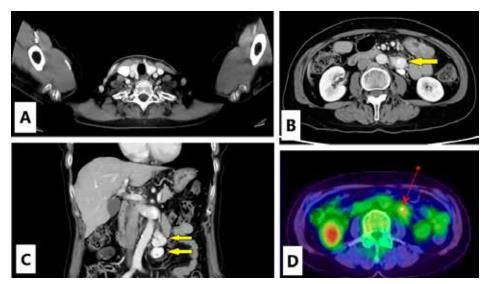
The thyroid gland was located in the normal position, and there were no neoplastic lesions in the neck. (A) On contrast-enhanced abdominal CT, the arrow indicates an approximately 2-cm mass on the left side of the abdominal aorta. (B) Arrows show masses contiguous above and below the aorta. Both lesions exhibited calcified internal areas. (C) On fluorodeoxyglucose-positron emission tomography (FDG-PET), the arrow indicates mild FDG accumulation in the intra-abdominal mass. (D)
